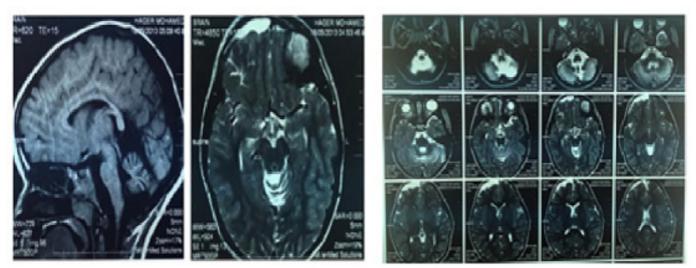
MRI brain of patient 1, showing right frontal subdural hygroma, severe cerebellar atrophy, cortical atrophy and white matter abnormalities.
